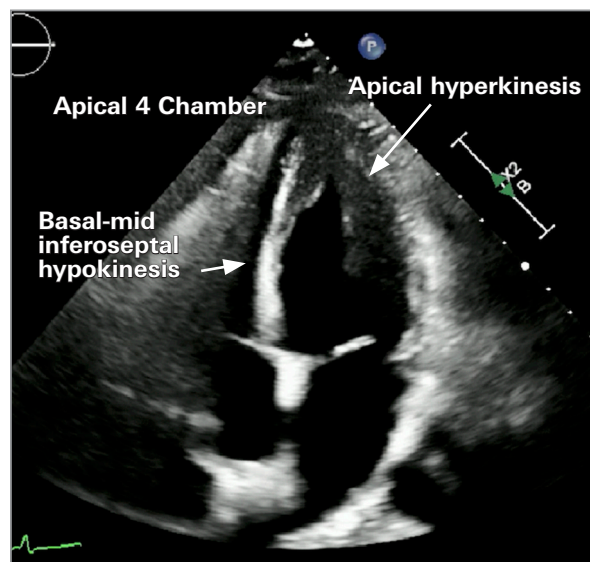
The apical 4-chamber echocardiogram view shows basal-mid inferoseptal hypokinesis and apical hyperkinesis.
